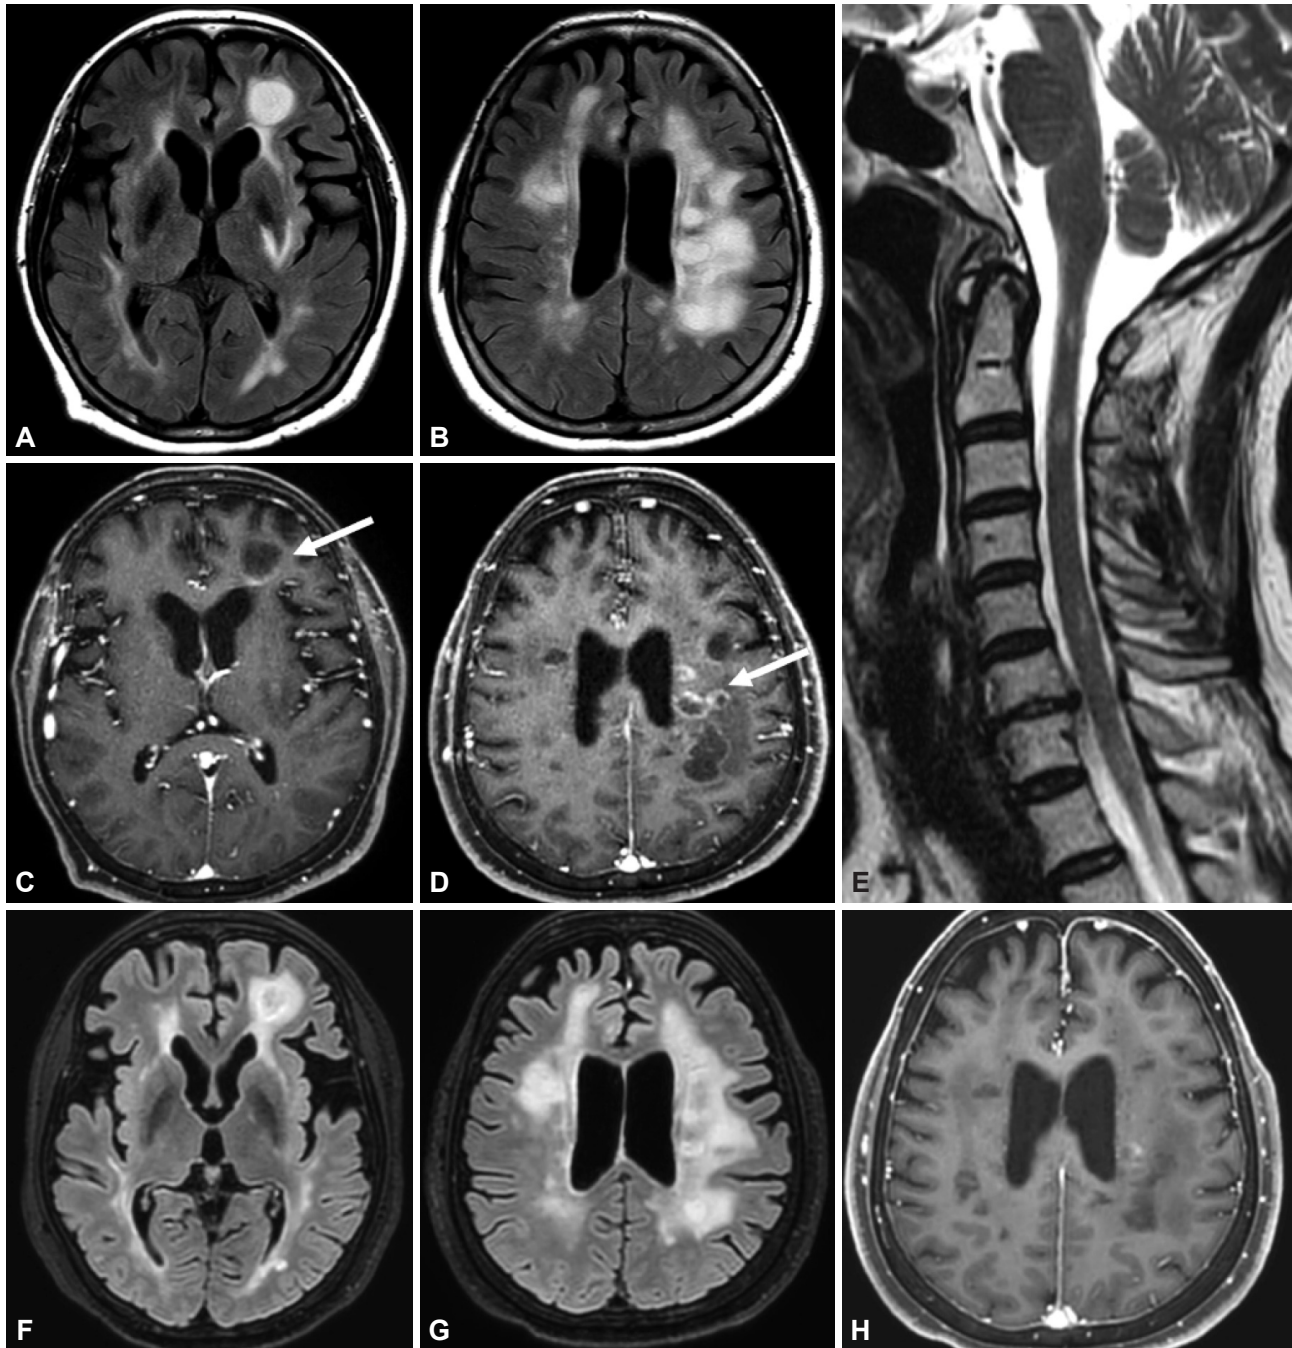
Brain and spine MRI of the present case. A and B: At admission, FLAIR images showed multiple hyperintense left frontal and bilateral periventricular white-matter lesions. C and D: Gd-enhanced T1-weighted images showed multiple open-ring enhancement patterns (arrows). E: Multiple cervical lesions with short-segment involvement were observed in spinal MRI. F, G, and H: Follow-up brain MRI after 2 weeks showed significantly decreased open-ring enhancement on the Gd-enhanced T1-weighted images, with minimal changes on the FLAIR images. FLAIR: fluid-attenuated inversion recovery, Gd: gadolinium, MRI: magnetic resonance imaging.
